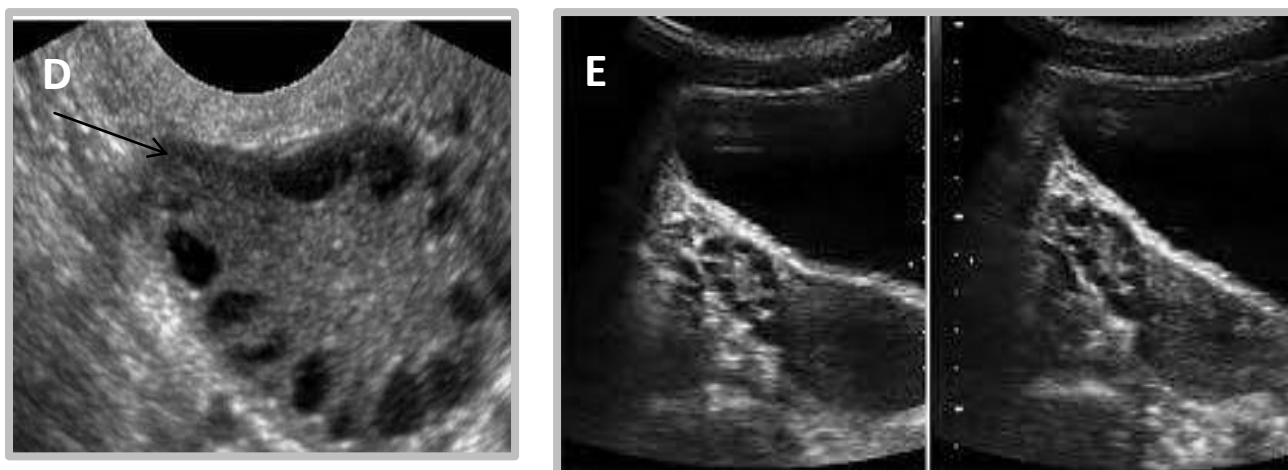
POS, A-Longitudinal transabdominal sonogram of an ovary. This image reveals multiple peripheral follicles. B- "Transverse endovaginal sonogram of the left ovary. This pic displays numerous peripheral follicles and hyperechoic stroma." "Annotation that none of the follicles is larger than 1.2 cm". C- This image "reveals multiple subcapsular follicles in together ovaries; the follicles are extravisible on the left side on this image". D- "Polycystic ovaries into together right and left ovaries, the ovarian length and width are increased as well as the ovarian area". "The follicle quantity, with a diameter mainly between Two and Five mm, is more than 8. The distribution within the ovaries is mainly peripheral. The increased and hyperechoic stroma occupies the center of the ovaries". E- "The total number of follicles per ovary or in a single cross segment was firm by summing follicle counts made in each grid section".
